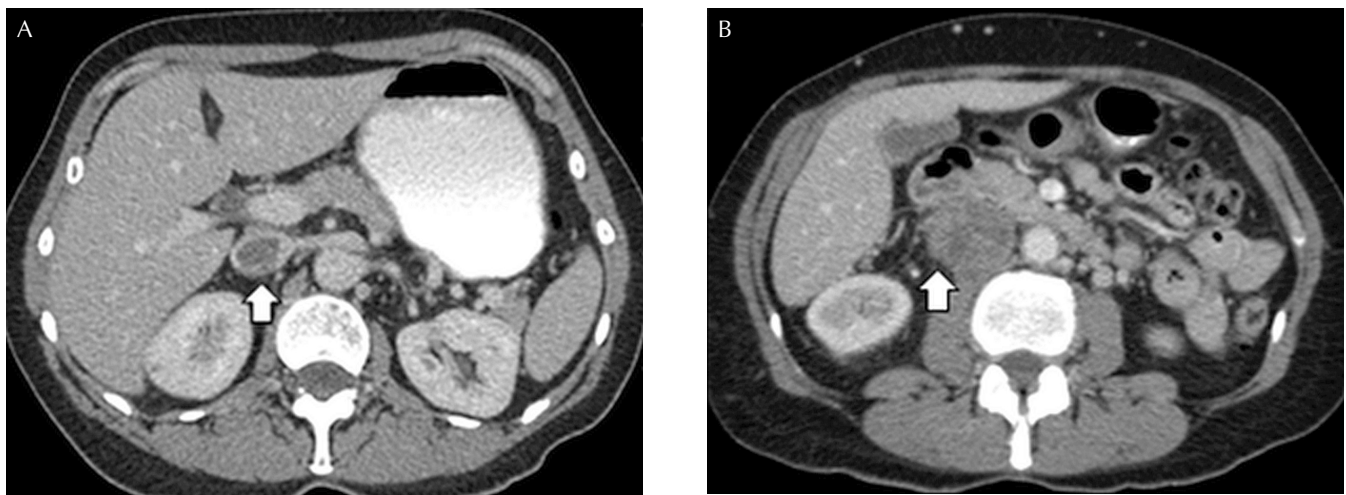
In a 50-year-old woman with an inferior vena cava (IVC) leiomyosarcoma, axial contrast-enhanced computed tomography demonstrates (A) an IVC-filling defect (arrow) with (B) local exophytic infiltration (arrow).
